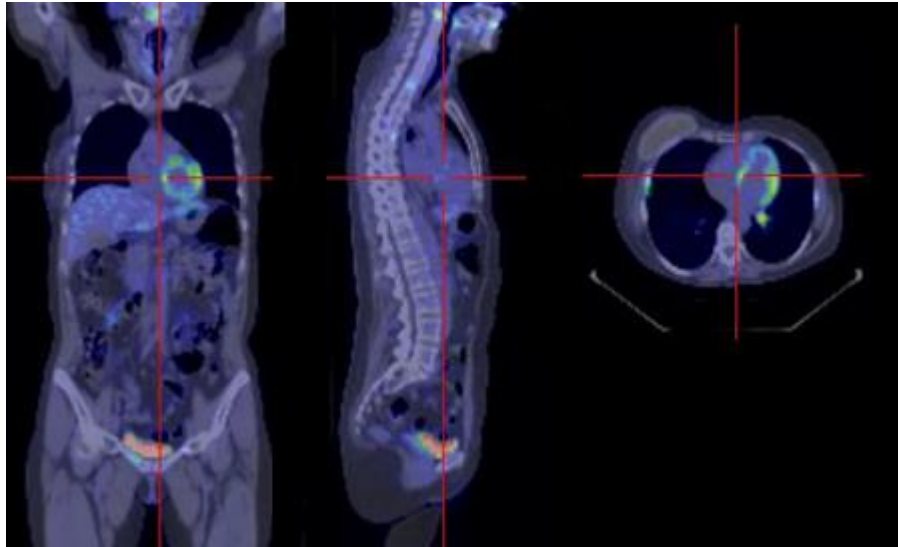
An example of PET/CT study (coronal, sagittal, and axial imaging planes).
